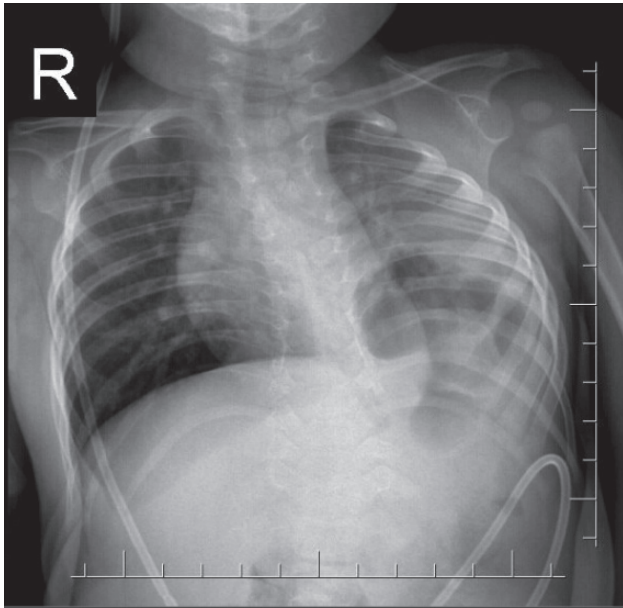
X-ray of the chest showed herniation of gut loops and spleen.
